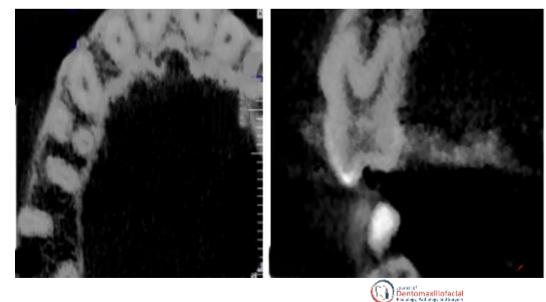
Double-rooted maxillary premolar in CBCT images and in axial (left) and coronal (right) views
